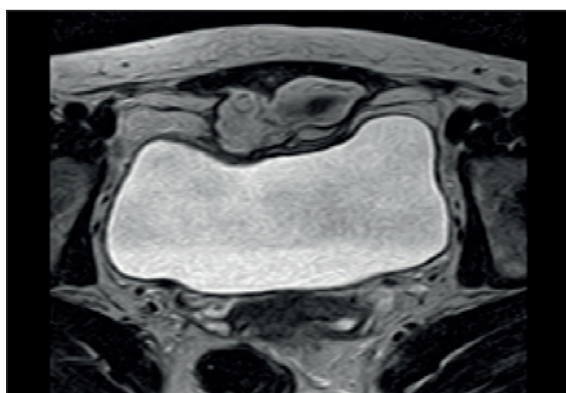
Post-contrast T1W axial pelvic MRI scan: Irregular hyper-intense mass invading *rectus abdominis* muscles, close to anterior bladder wall but without signs of infiltration was found
